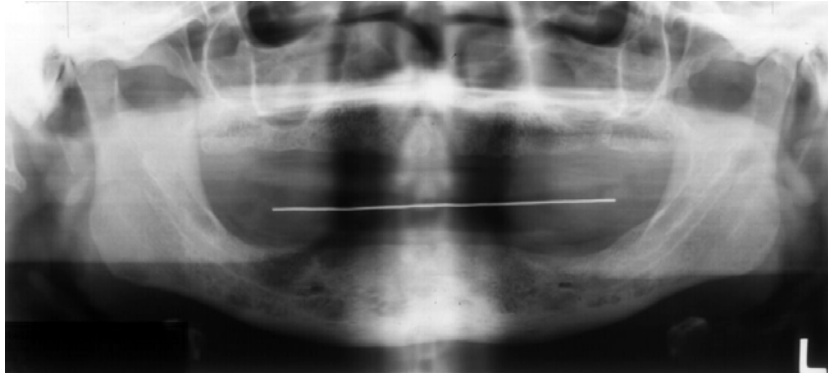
Panoramic radiograph of the edentulous subject
